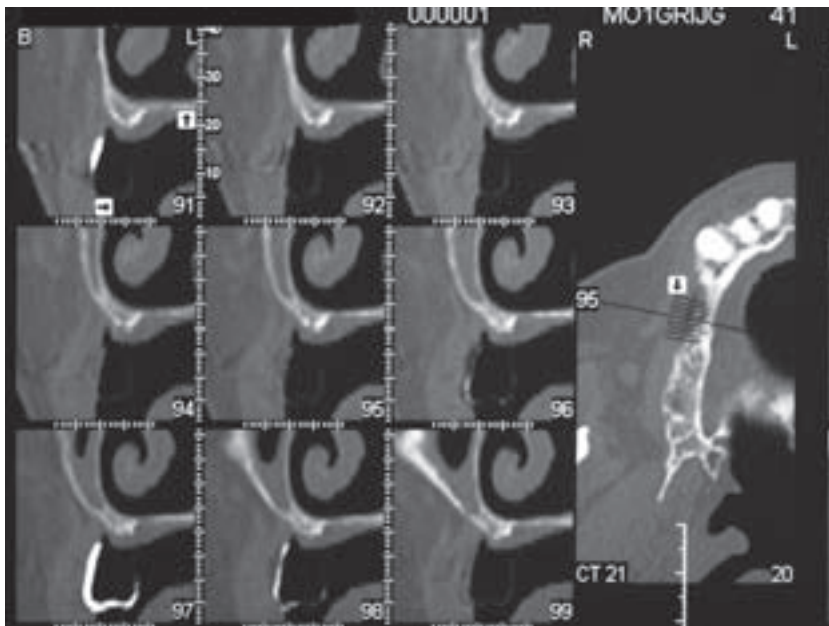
Cross-sectional CT-scan view indicating that the proposed restoration is not below the sinus.
